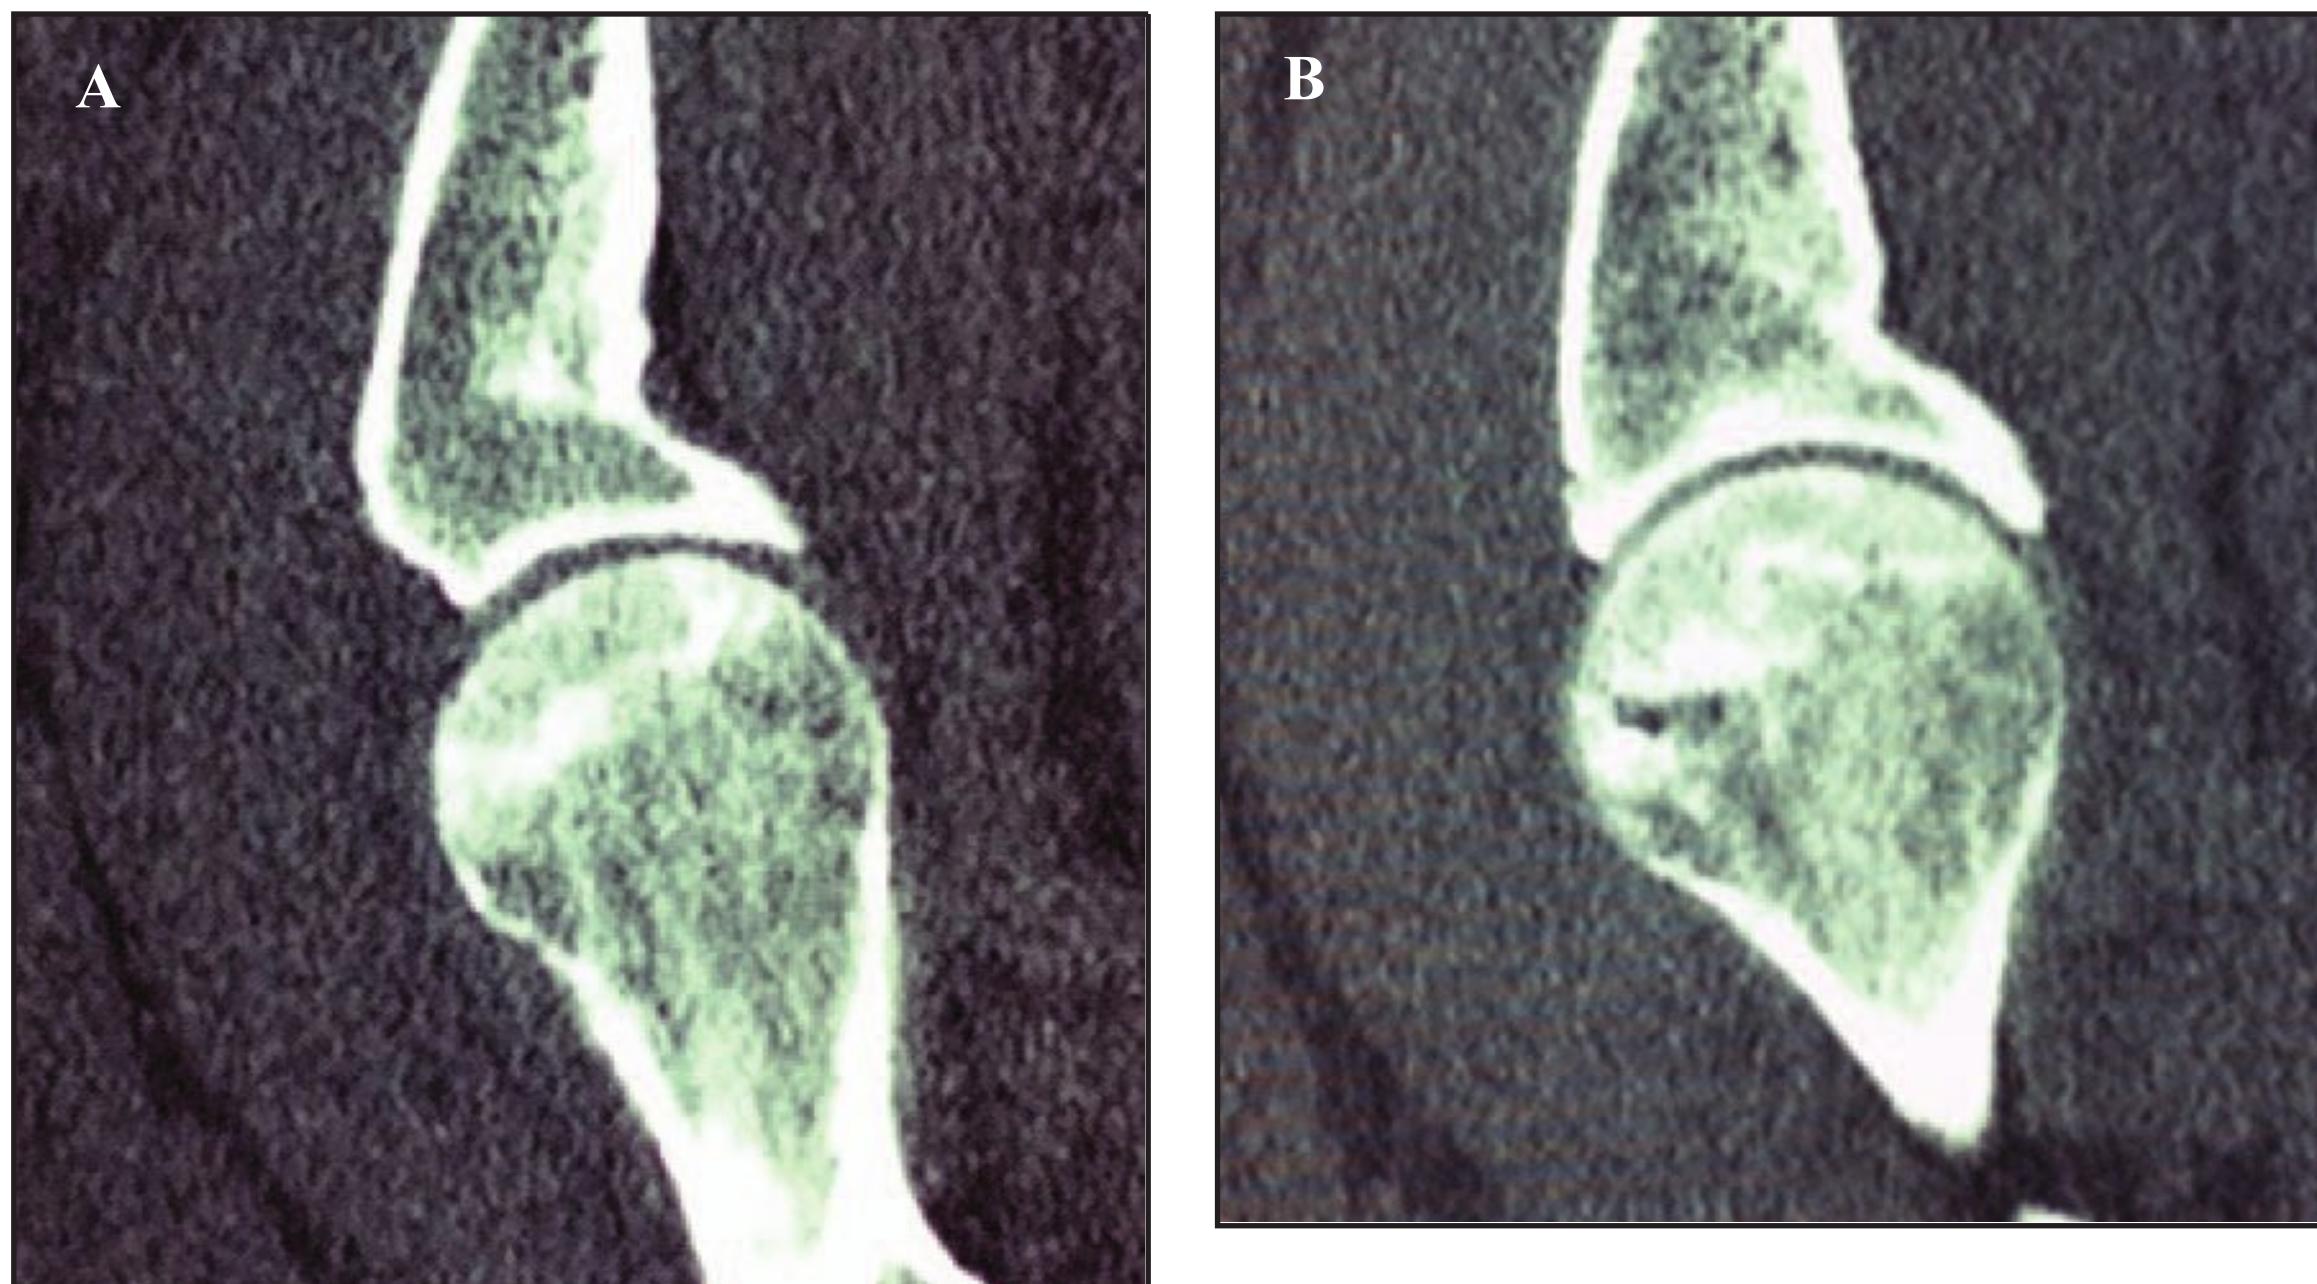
Computed tomography of osteonecrosis.
